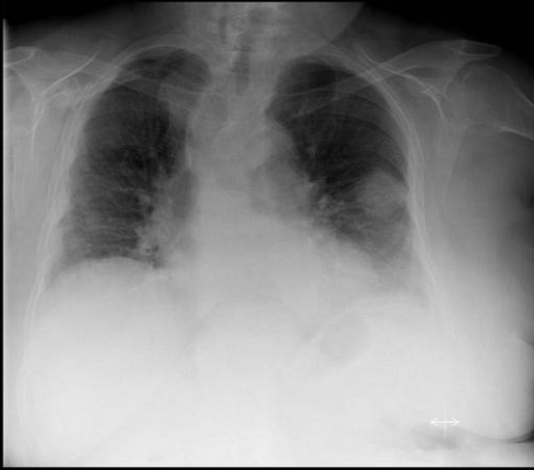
Round pneumonia due to *Streptococcus pneumoniae*. Chest radiograph (a) shows a round area of consolidation mimicking a mass in the left lung.
